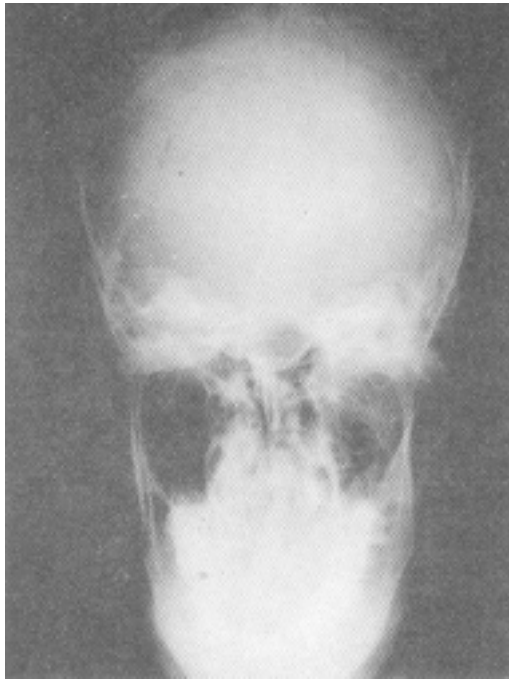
X-ray skull AP view showing lytic area in the parietal bone
